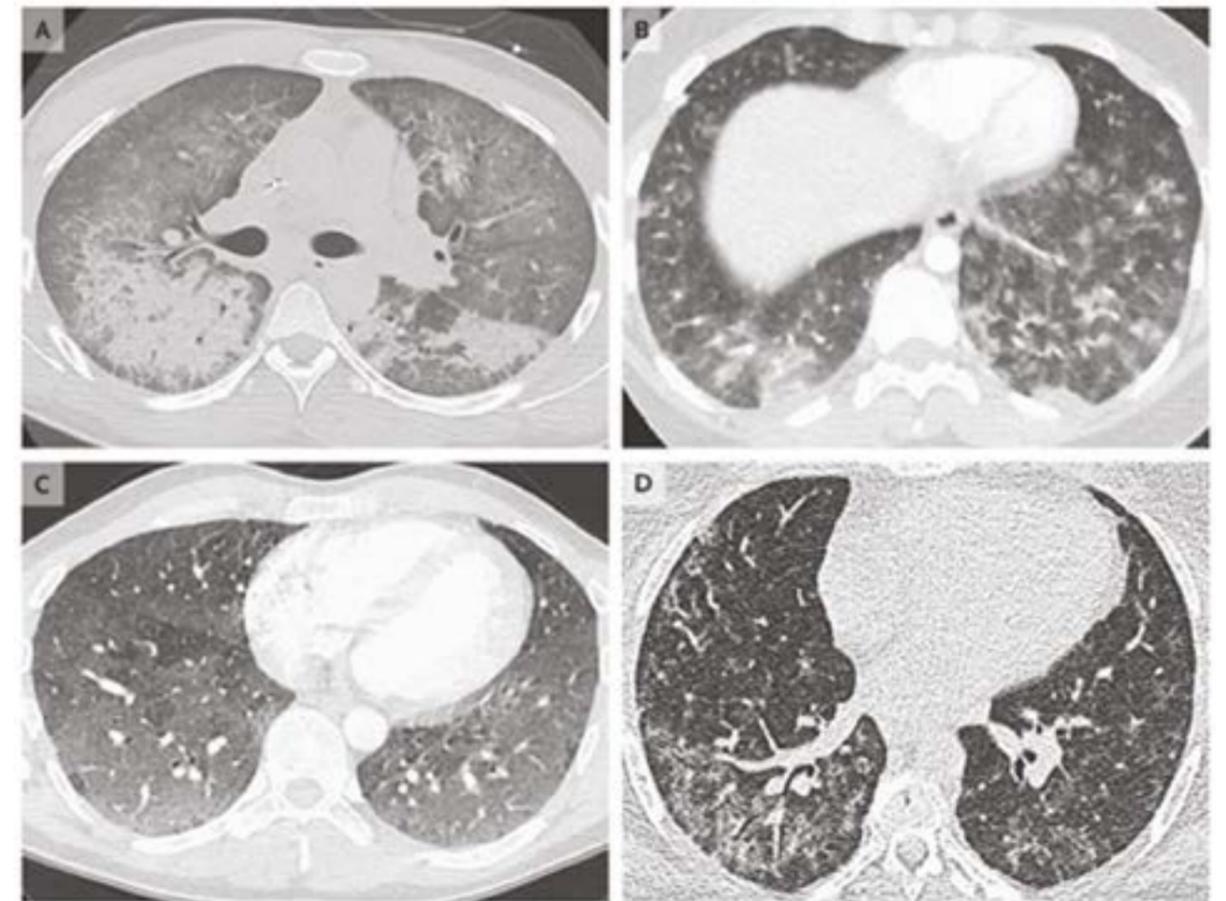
Computed Tomographic (CT) scans of the chest obtained from patients with vaping-associated lung injury.
